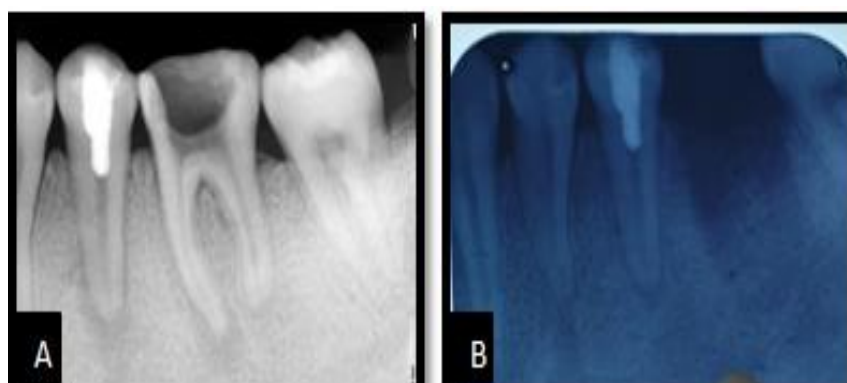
A: One month follow up radiograph which showed decrease in the size of periapical radiolucency B: Seven month follow up radiograph showing complete resolution of the periapical radiolucency
